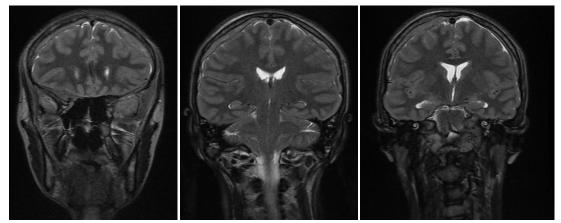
Image showing sections of the brain MRI, T2 sequence, in the frontal plane showing the thickening of the meninges in iso-signal
